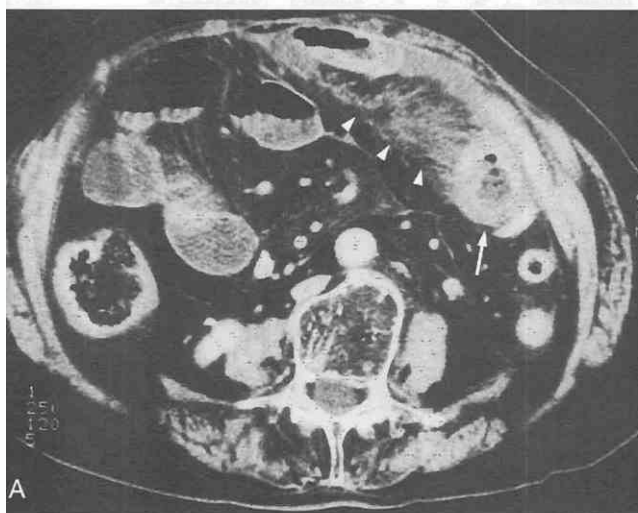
Strangulated small-bowel obstruction caused by bands and adhesion. A and B, CT scan shows different degrees of contrast enhancement (arrows) in the thickened bowel wall of the same strangulated segment. Diffuse engorgement and haziness (arrowheads) are seen in the vasa recta of the regional mesentery. (From Ha HK, Rha SE, Kim JH, et al: CT diagnosis of strangulation in patients with small bowel obstruction: Current status and future direction. *Emerg Radiol* 2:47-55, 2000.)
